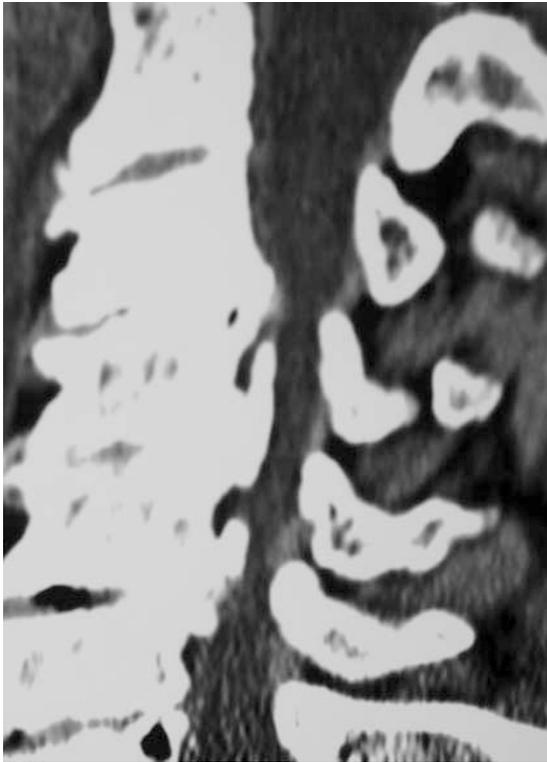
The parasagittal 2D-CT scan demonstrates mature multilevel continuous OPLL extending from C3 to C7
